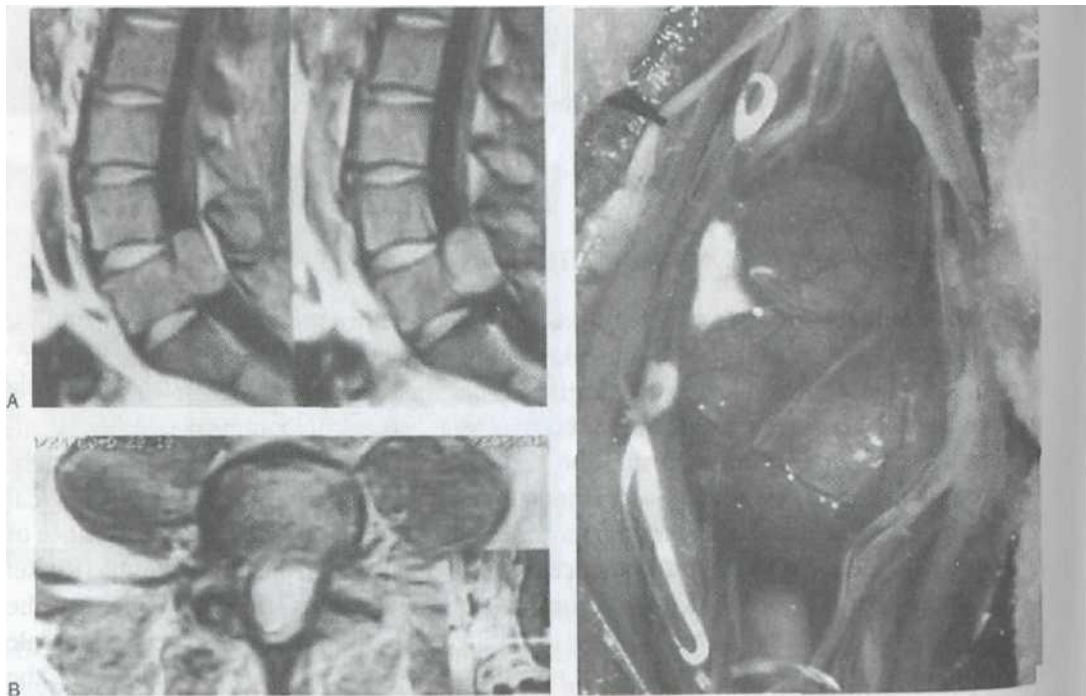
Schwannoma. Sagittal pre- and postcontrast lumbar magnetic resonance images (MRI) (A) and postcontrast (B) axial MRI shows a globoid and homogeneously enhancing intradural lesion at L-5. (C) Intraoperative photograph showing a well-circumscribed tumor with a smooth capsule that is adherent to the cauda equina
